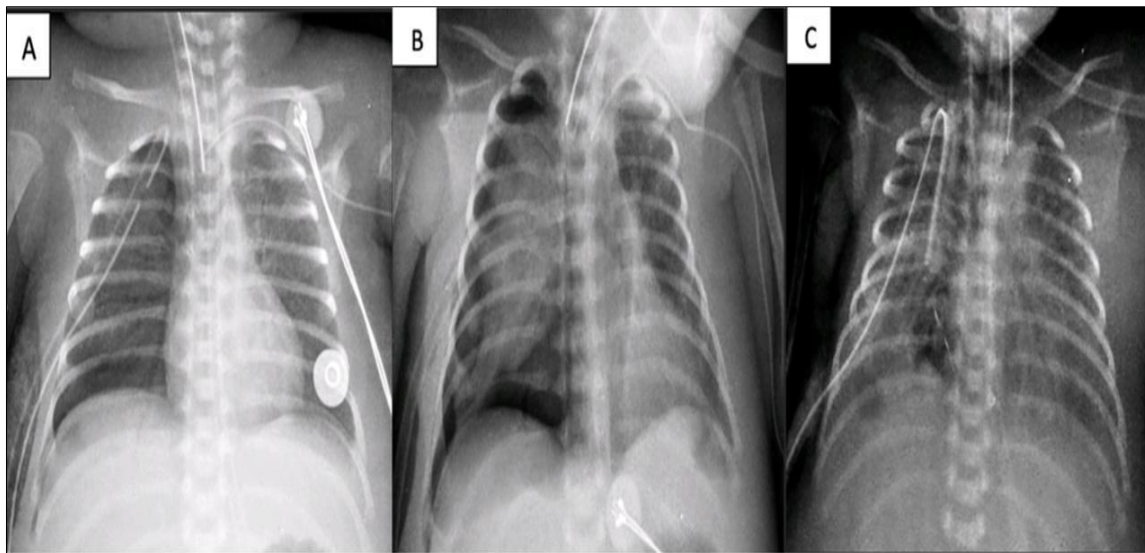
A) Chest x-ray post 1st ABPP. B) Chest x-ray post 2nd ABPP. C) Chest x-ray post fibrin patch.
